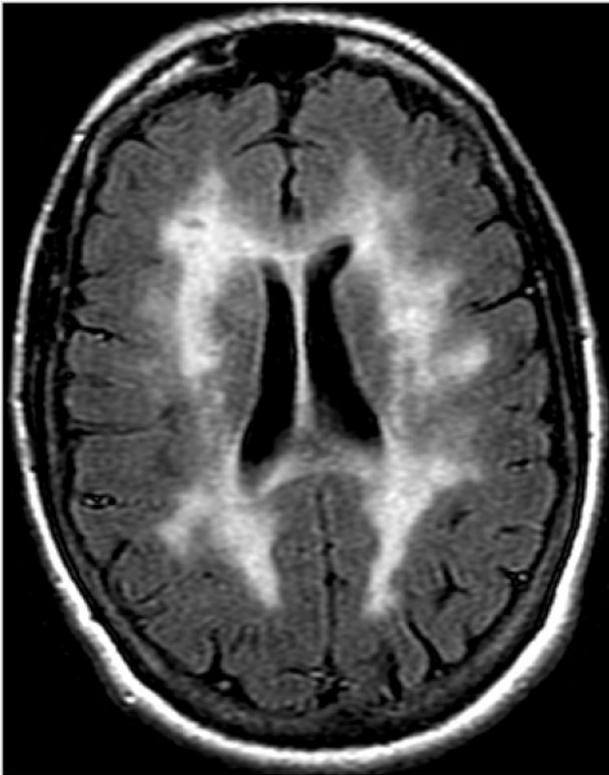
Magnetic resonance FLAIR in a patient with CADASIL showing typical demyelination involving the temporal pole and external capsule
